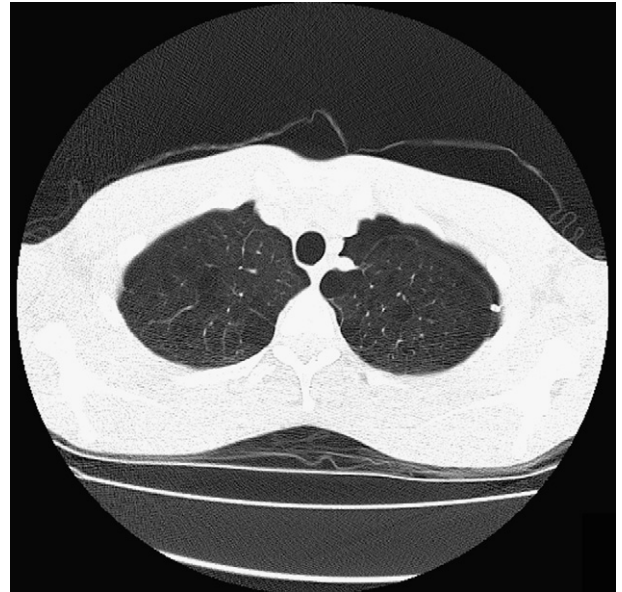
High resolution CT scan of chest showing apical bullae.
